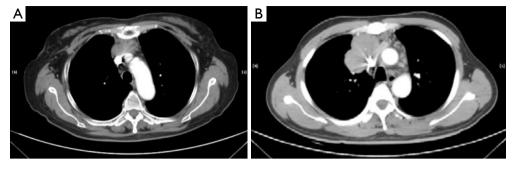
Tumor invasion of vessels is showed on CT. (A) When the tumor abutted \geq 50% of the vascular circumference with loss of the fat plane and the vascular wall is rough, involvement of the vessel was considered present; (B) when the vascular lumen was directly penetrated by the tumor, involvement of the vessel was also considered present.
